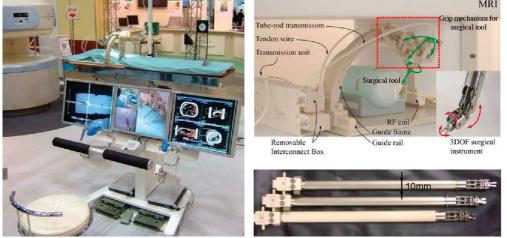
MRI image-guided surgical system, reprinted by permission from Springer Nature: Springer Nature [53].
